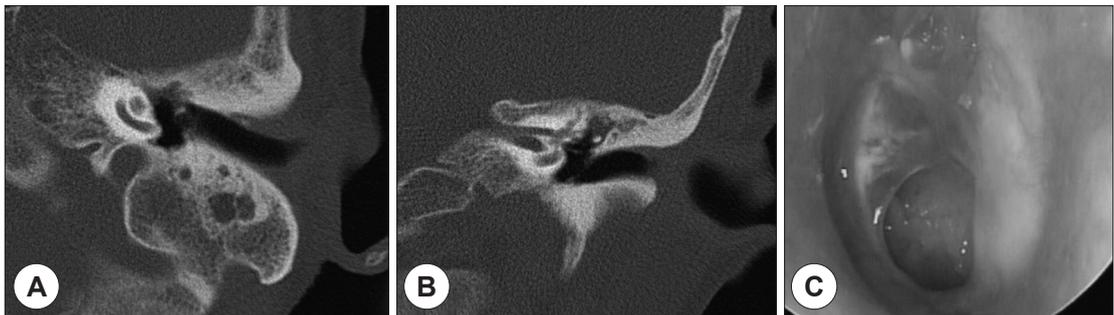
Follow-up temporal bone CT scan (A and B) and ear drum finding (C) at 3 months post-presentation. Temporal bone CT scan showed well aerated middle ear space, but soft tissue density in sclerotic mastoid cavity (A : axial view, B : coronal view). Otoloscopic exam shows dry medium sized perforation of the tympanic membrane.
